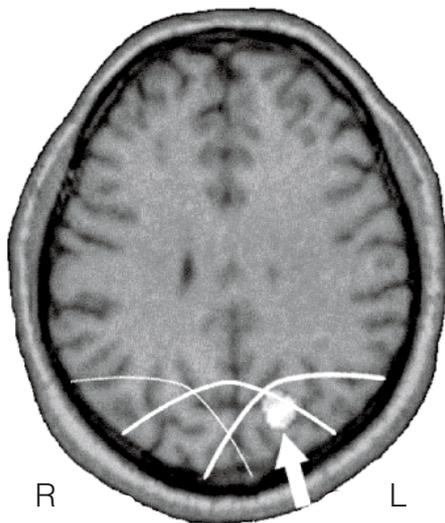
Activation due to grating orientation (relative to spacing) observed in previous PET study¹ superimposed on an axial, T-1-weighted MRI slice derived from one subject who participated in both the PET study and the present study. Arrow, activation. Talairach coordinates of centre of activation: $x = -20$, $y = -71$, $z = 32$. Isopotential lines of the TMS-induced electric fields corresponding to 90% of the resting motor threshold are also superimposed on the MRI. Brain regions on the concave side of the curves are exposed to electric fields above the threshold of known physiological effects. The heavy curves refer to TMS at the (effective) M4 and L3 sites; the thin curve refers to the (ineffective) R3 site. Similar calculations (data not shown) indicated the compatibility of the effectiveness of TMS at other occipital sites (M2, L6, R6) in the orientation task with the ability to evoke physiological effects at the PET activation locus.
